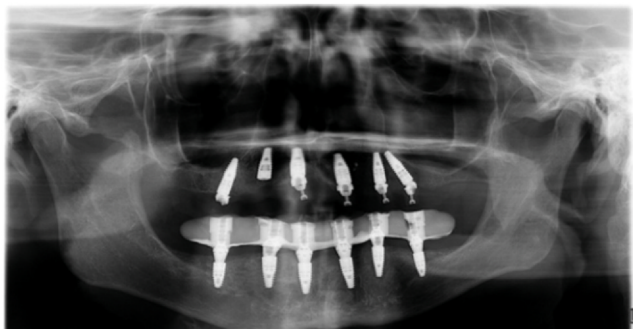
Panoramic radiograph immediately after placement of maxillary implants.
